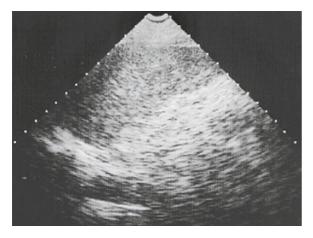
Splenic abscess. This spleen was considered homogeneous using ultrasound, whereas CT revealed an abscess. In these cases, especially in plethoric, poorly echoic patients, the low echogenicity of the image should be recognized and considered as a limitation, in order to request other imaging modalities
